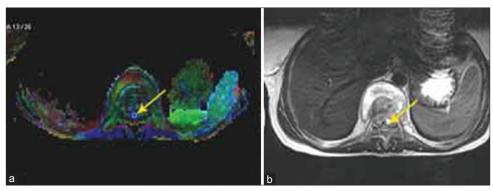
(a) Region of interests at serial intervals (yellow arrow) drawn at the site of lesion. (b) corresponding axial T2 magnetic resonance imaging shows prevertebral and epidural collection
